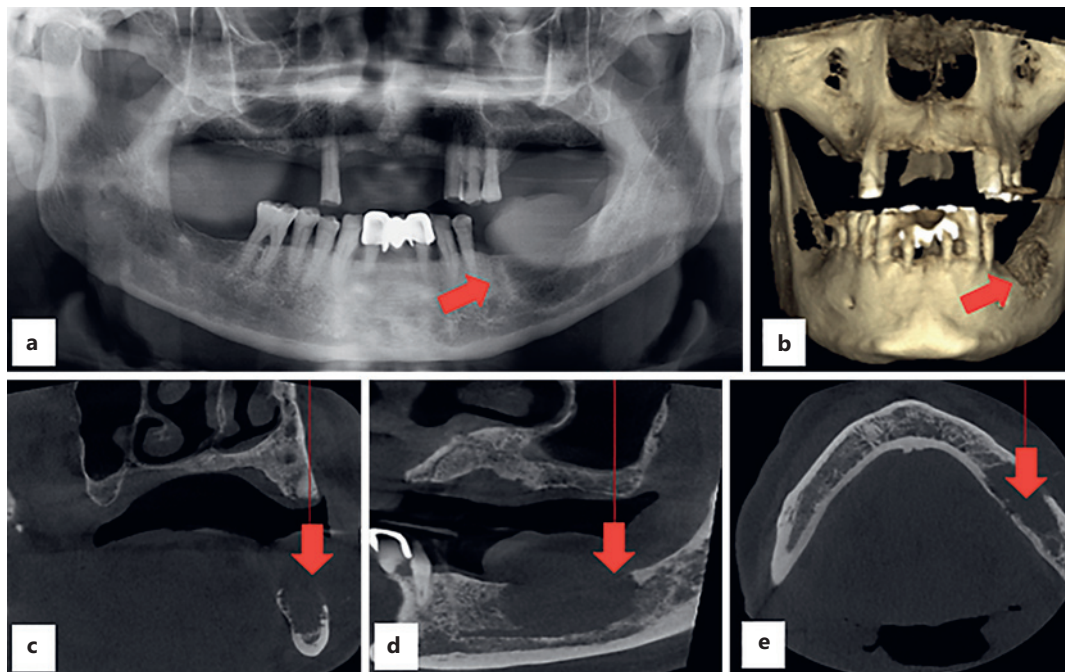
Orthopantomography showed generalized severe bone loss (a, b); undermining at the level of the left mandibular body and isodense image with defined limits and irregular edges; and conditioning a localized permeative pattern in the lower molar area left that extends from the crestal area of the residual ridge to the roof of the dental canal, generating erosion of the same (c–e).
